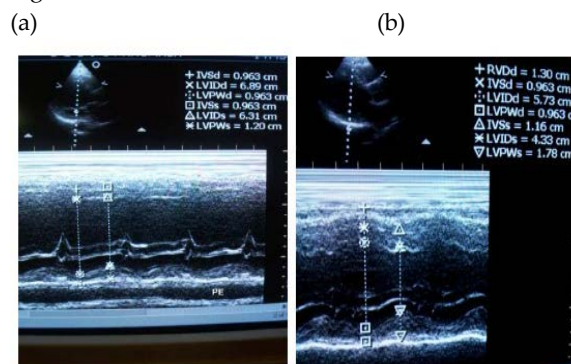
A-B: M-mode parasternal long axis views of left ventricle; (A): Dilated LV, global hypokinesia, LVEF of 16 -20 % with pericardial effusion (PE); (B): Echo after 3 months: LV size markedly reduced, LVEF of 45-50% and no pericardial effusion.
